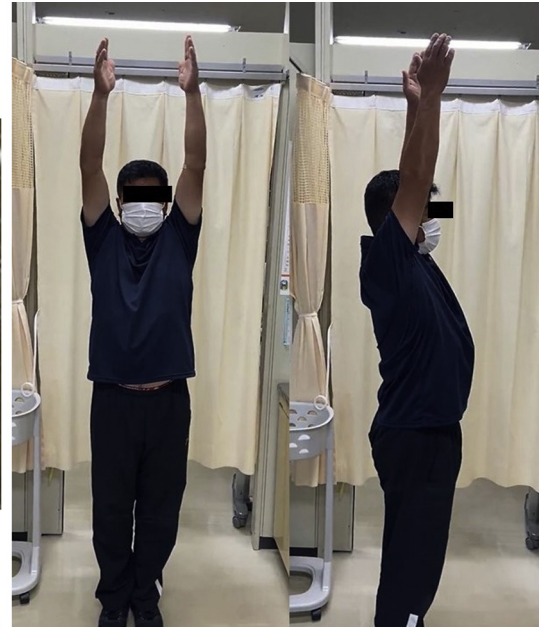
Image and ROM at two years postoperatively of the right shoulder. Left: Coronal T2-weighted magnetic resonance image. Right: Elevation angle of the shoulder.
